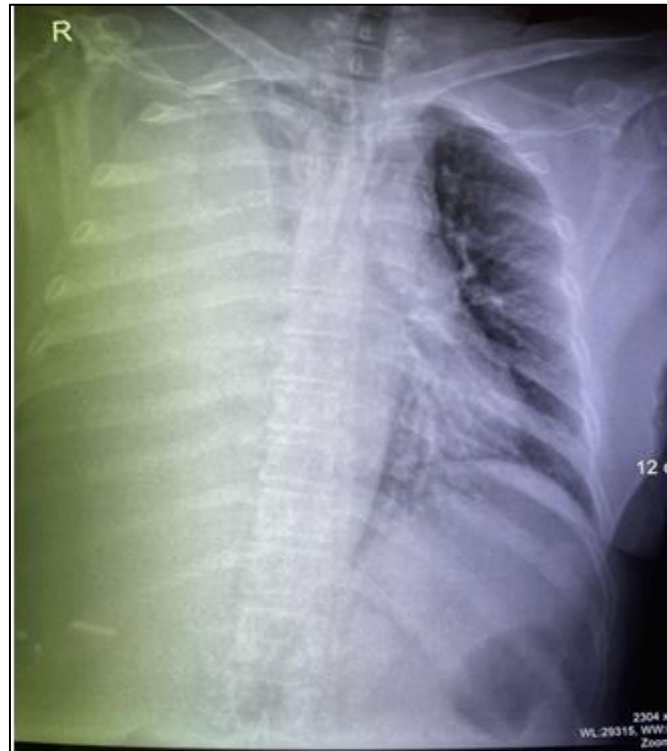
Chest X-Ray Demonstrating a Homogeneous Opacity of the left Hemithorax, Consistent with Massive Pleural Effusion and Significant Fluid Accumulation.
